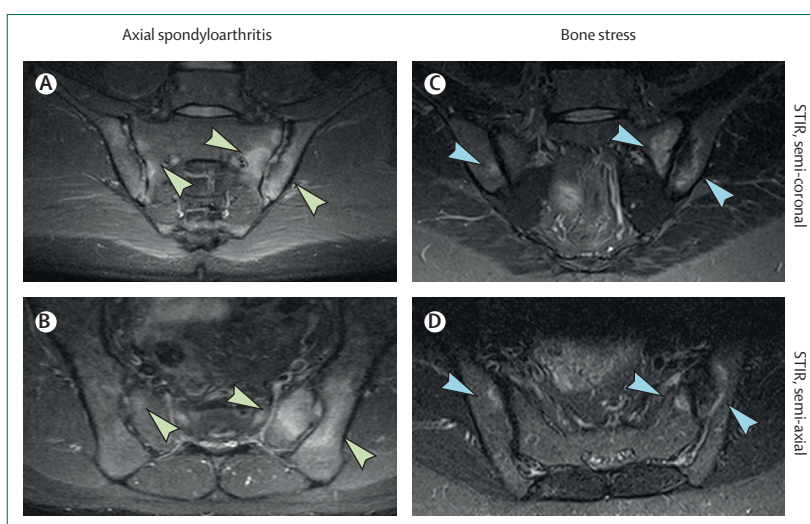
Imaging findings of bone marrow oedema related to axial spondyloarthritis and bone stress MRI (ie, STIR sequences, in semi-coronal [A and C] and in semi-axial orientation [B and D]) of sacroiliac joints. (A, B) Typical for axial spondyloarthritis is the large extent and intensity of the bone marrow oedema (green arrows), here found bilaterally, both at the sacral and the iliac bone and in the middle part of the joint, where also the cartilage is located anatomically. (C, D) Typical for non-axial spondyloarthritis suggestive bone marrow oedema (ie, bone stress) is shown as the smaller extent and lower intensity signal (blue arrows), which is especially located in the upper or ventral part of the joint (here also at the sacral and iliac bones) where anatomically less or no cartilage is located. STIR=short tau inversion recovery.
